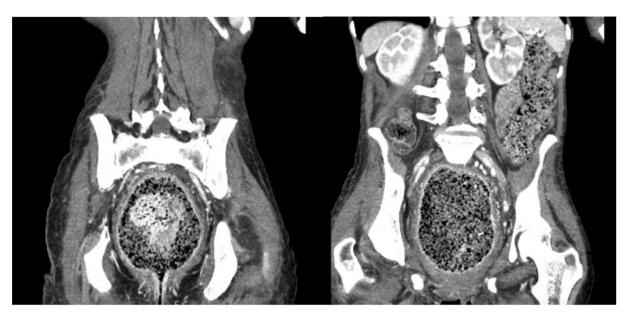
CT scan of the abdomen and pelvis on initial presentation showing the dilated rectum, rectal wall thickening with surrounding edema and rectal bezoar (coronal views).
